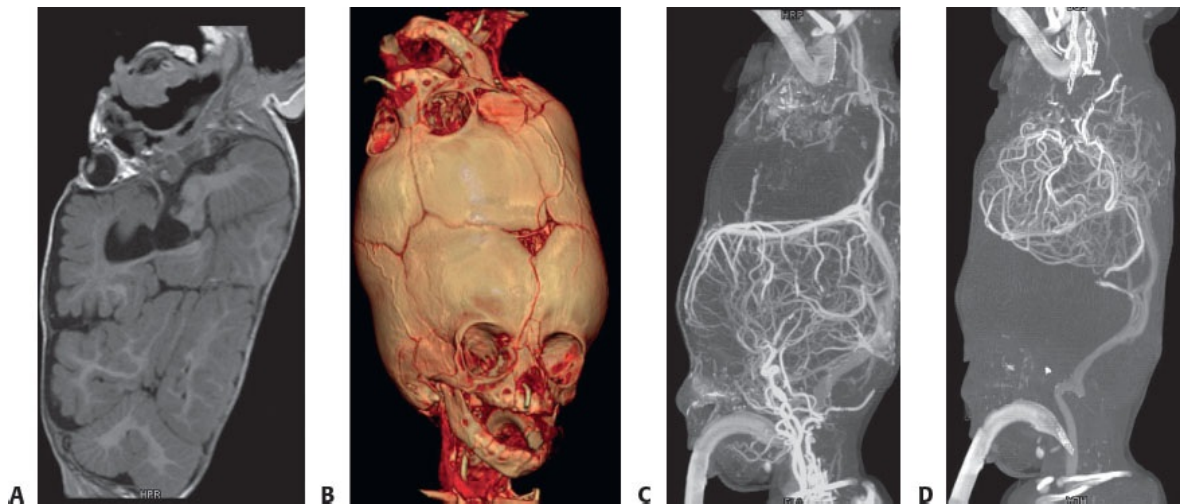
• Radiological imaging. Twin A is at the top and Twin B at the bottom. A. MRI delineates brain anatomy and areas of cortical confluence. B. CT with 3D reconstruction delineates skin bone and vascular
